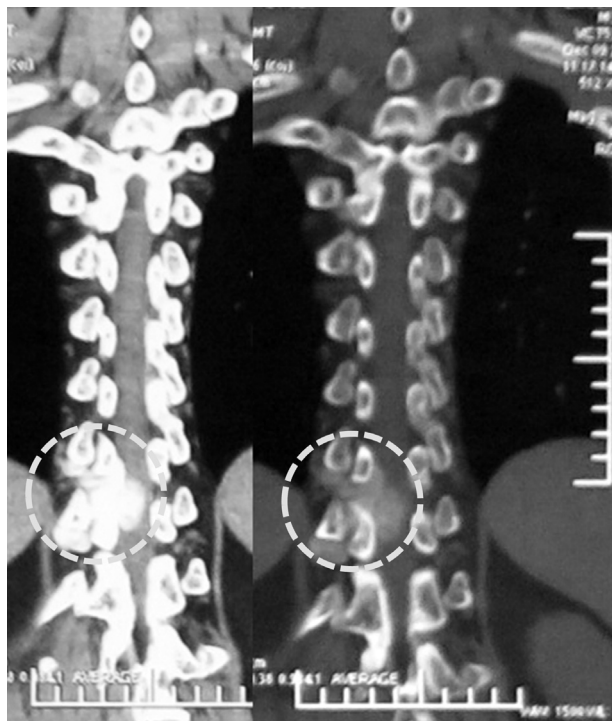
Computed tomography of the thoracic spine. There was a random-shaped lesion with slightly high density in the spinal canal at level T8–T9. It eroded tissues outside the spinal canal along the right foramina; the bone of the right articular process was involved.
